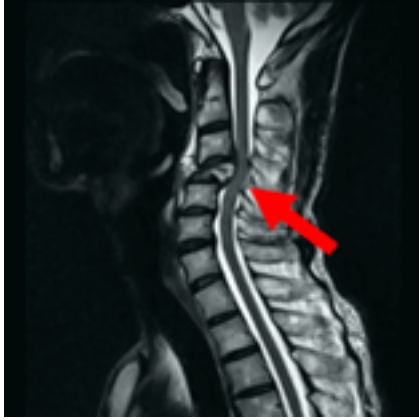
Magnetic resonance imaging shows a pathological fracture in the cervical vertebrae, stricture of the vertebral canal and the oppression of the spinal nerve (arrow).
